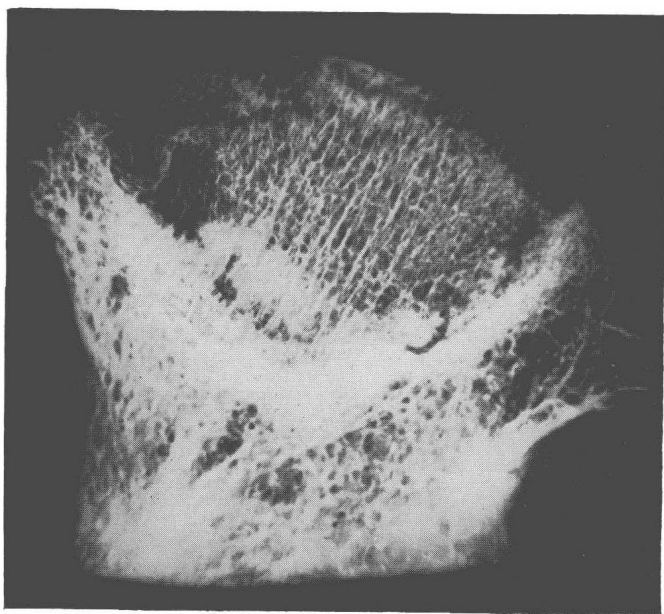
Radiograph of a femoral head excised 4 years after fracture, showing an area of segmental necrosis. The fracture has united and the capital fragment is partly re-ossified. The goblet-shaped area of sclerosis is the margin of the re-ossified area. The bone between it and the articular cartilage is necrotic
